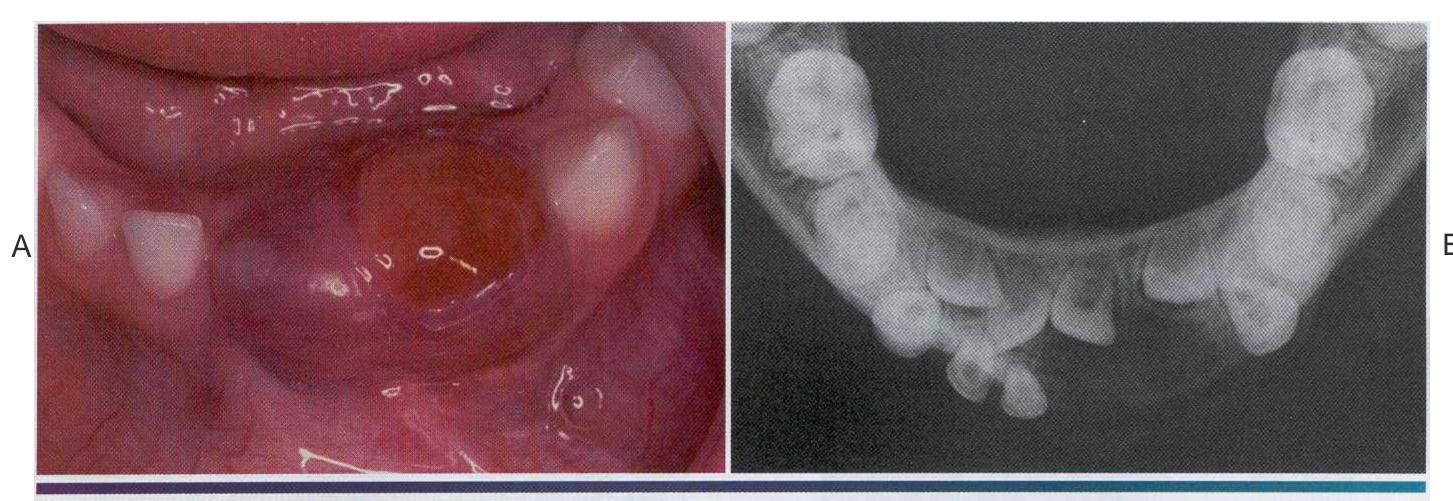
Central giant cell granuloma. A, A bluish-purple mass is present on the anterior alveolar ridge of this 4-year-old white boy. B, The occlus all radiograph shows a radiolucent lesion with cortical expansion.
